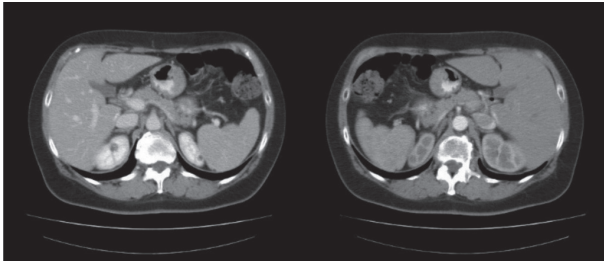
55-year old woman affected by left colon adenocarcinoma who undergoes to left hemicolectomy. We may observe in this preoperative CT diffuse low attenuation of the liver
